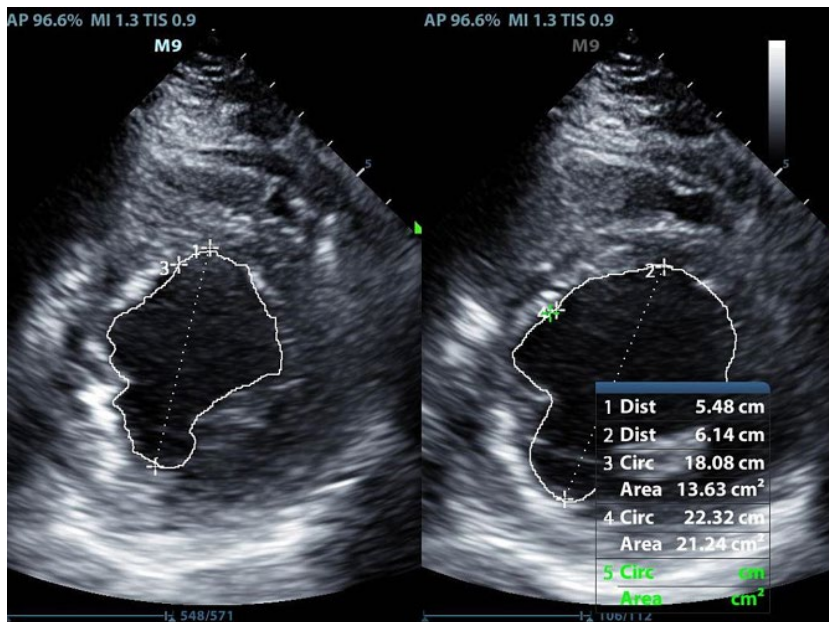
A parasternal short-axis (PSAX) mid-papillary view in systole (left) and diastole (right) showing the methods of estimating both fractional shortening (FS) and fractional area of contraction (FAC). The FS is $(6.14 - 5.48)/6.14 = 0.26/6.14 = 4\%$. The FAC is $(22.3 - 13.6)/22.3 = 8.7/22.3 = 39\%$. PSAX and PLAX views from the apex to the aortic valve can be seen in Videos 5.1 and 5.2. These clips reveal hypokinesis of the inferior wall, which leads to the artefactually low FS obtained by these measurements. Systematic visual evaluation of the entire ventricle in at least two orthogonal planes will decrease the potential for error caused by static measurements. Many studies have confirmed the accuracy of visual estimation in the assessment of LVEF. Figure © A. J. Dean.
